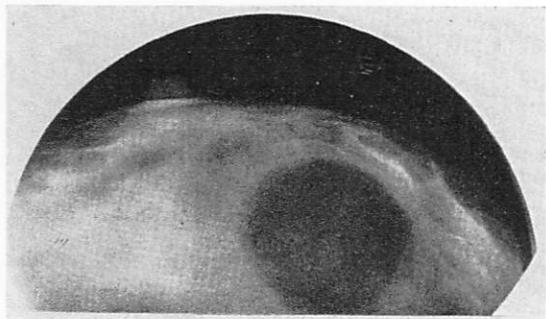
Encapsulated tumor, transparent to the roentgen rays, characteristic of galactoceles with butter-like content.
